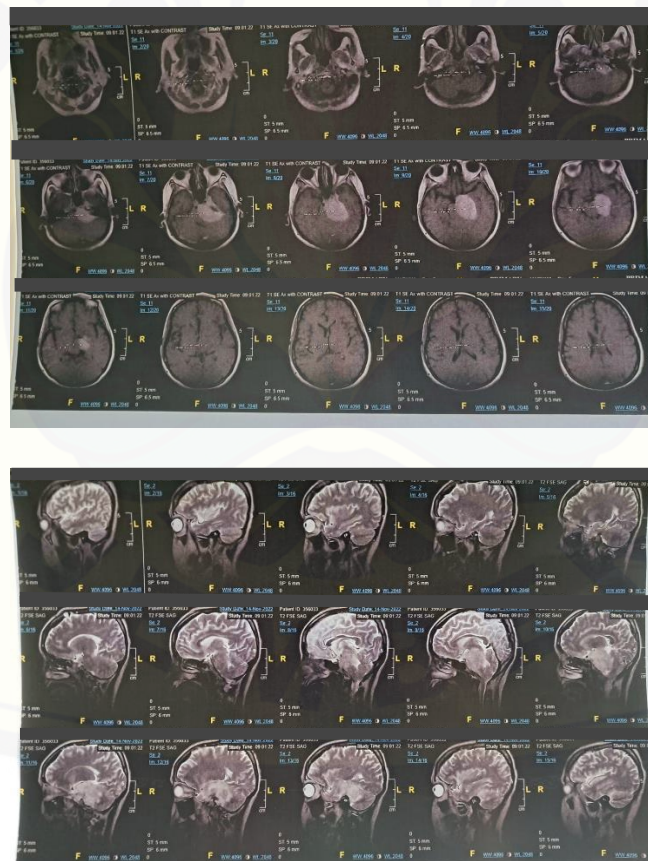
Preoperative Head MRI
